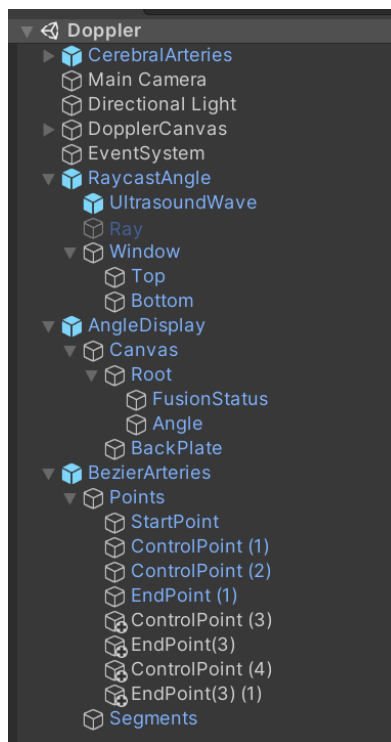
Scene tree for test scene in HoloNeoDoppler
